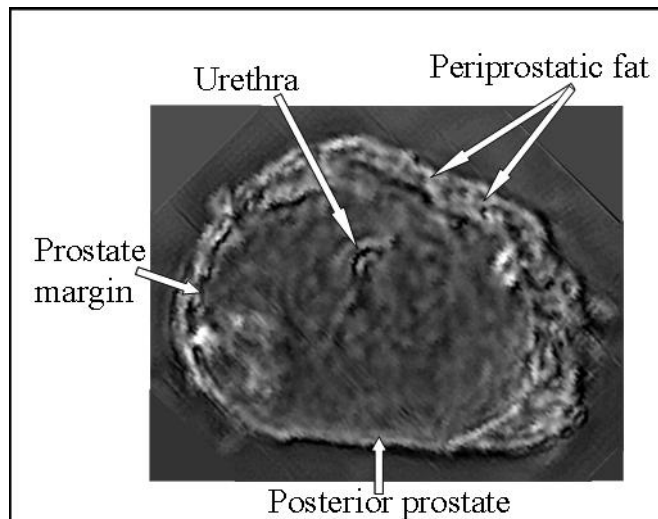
VA image of an excised prostate showing an axial section. This image with  $\Delta f = 6$  kHz shows clear anatomy of the prostate as compared to visible inspection of the section. Noted are periprostatic fat, urethra, posterior prostate and the prostate margin. Unlike ultrasound imaging, VA images have no speckle. (Reproduced with permission from [23]).
